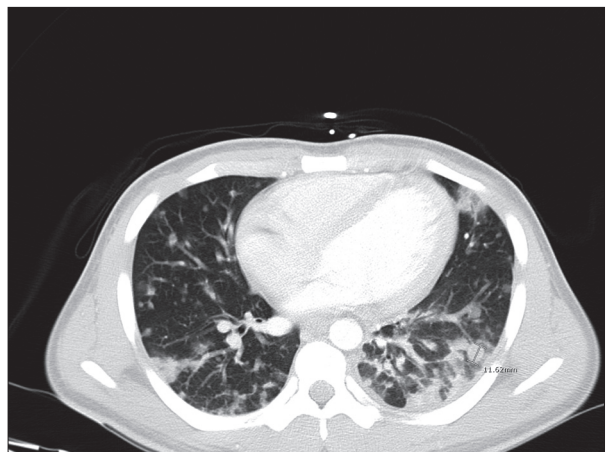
CT Chest with contrast: There are numerous bilateral pulmonary nodules of varying sizes, ranging from under a millimeter to 2.5 cm in the superior segment of the left lower lobe. The more peripheral lesions are larger in size and demonstrate early central cavitation.
